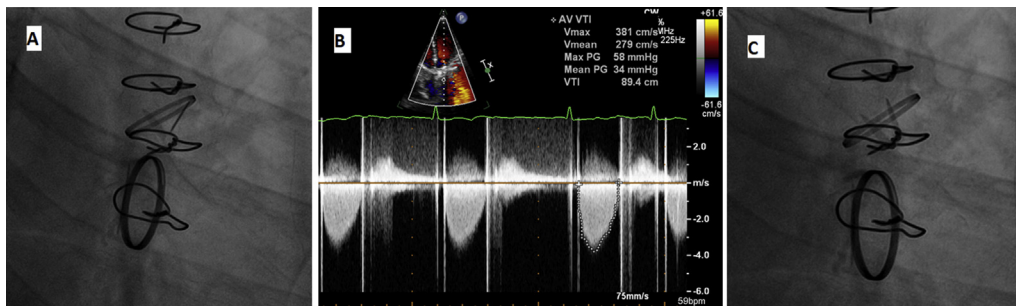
A: Fluoroscopy showed stuck one of the AV leaflets in a closed position. B: Continuous doppler flow on AV, the mean PG is 34 mmHg. C: After 48 h of Alteplase the stuck leaflet was released.
